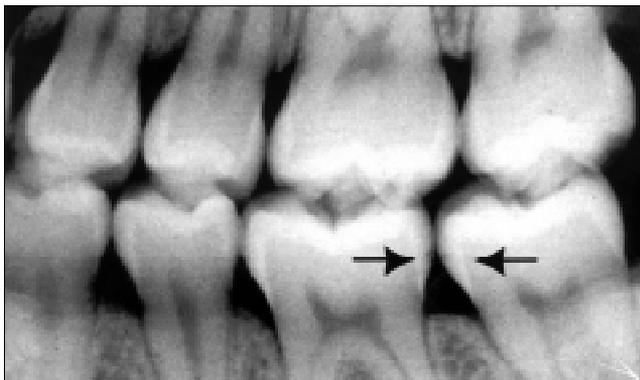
Case 1: 14 years, 6-month-old female. Left bitewing radiograph.
